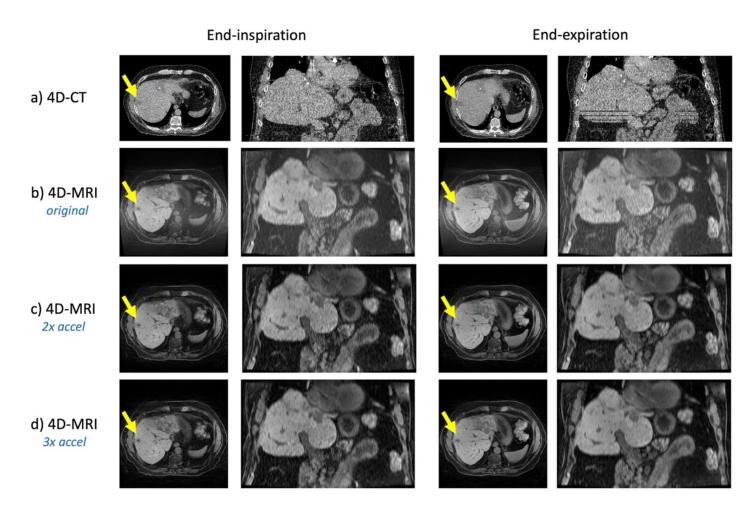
End-inspiration and end-expiration a) 4D-CT and 4D-MRIs reconstructed using b) original 3000 spoke sampling, c) 2x acceleration, and d) 3x acceleration. The liver tumor is annotated using the yellow arrow in all axial planes. Note that the 4D-MRI improves tumor contrast and resolves respiratory-induced motion artifacts relative to the 4D-CT.
